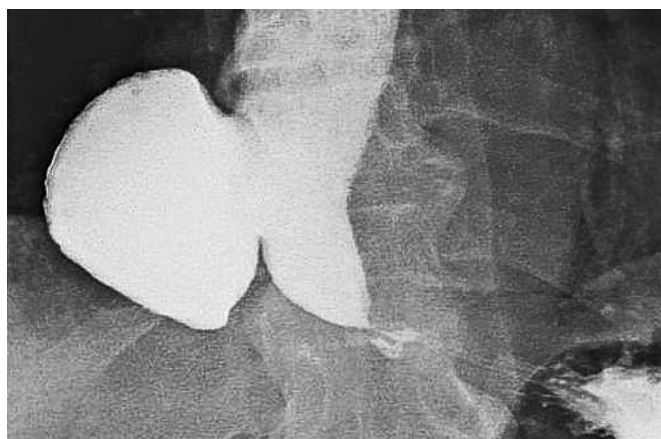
Barium radiograph showing an epiphrenic diverticulum with a "bird's beak" configuration of the distal esophagus.
